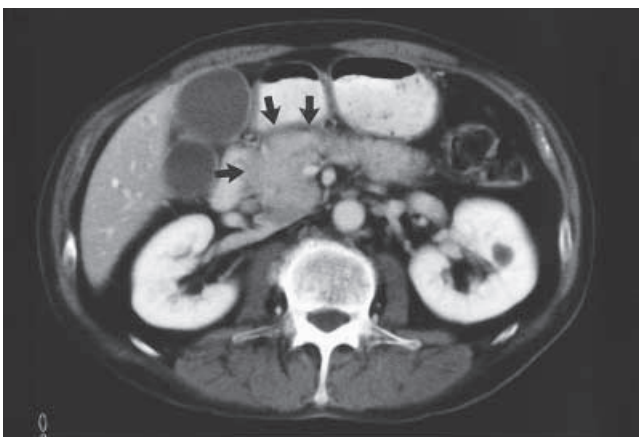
Computed tomography (CT) reveals swelling of the pancreas, shown more prominently in the head. A low-density capsule-like rim (*arrows*) is shown in parts the enlarged head of the pancreas, near the duodenum and the renal vein
